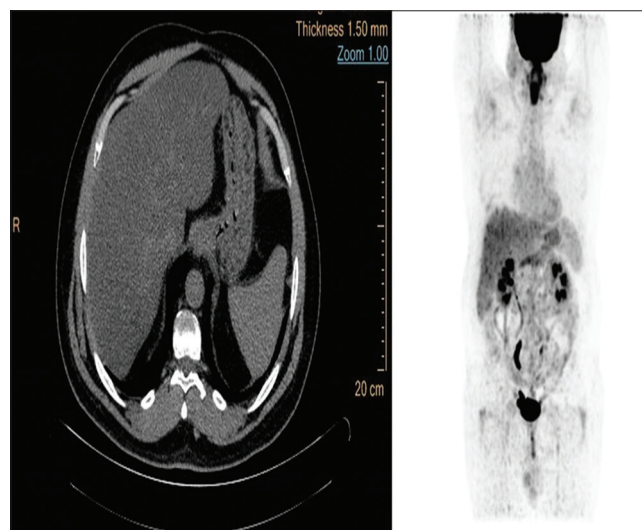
Representative example of steatotic patient. Maximal intensity projection and axial computed tomography (CT) image for a 45-year-old male patient addressed for interim positron emission tomography/CT of Hodgkin lymphoma scored Deauville score 2. Body mass index (BMI) was increasing throughout follow-up. BMI; initially was 29.8 kg/m², BMI at interim and EOT was 34.3 and 33.6 kg/m², respectively
